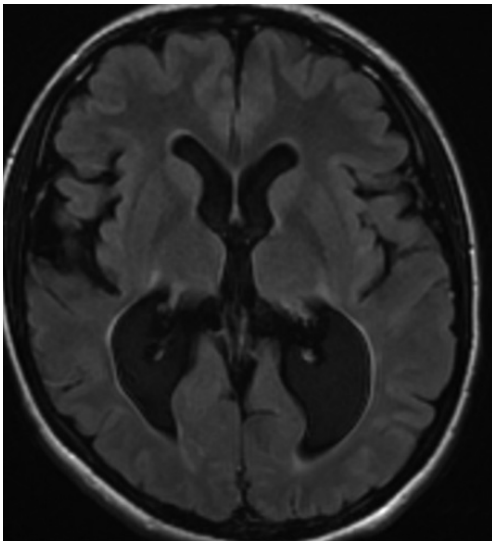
19-year-old patient, former premature infant, with athetosis, dystonia, and spastic quadraparesis. The axial FLAIR image demonstrates marked thinning of the posterior periventricular white matter, minimal periventricular gliosis, and the small size of the thalami. These are typical findings of white matter of prematurity.
